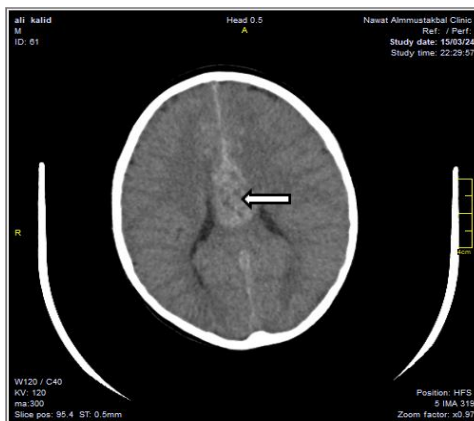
Initial brain CT showed no epidural or subdural hemorrhage, but a traumatic subarachnoid hemorrhage in the interhemispheric fissure with corpus callosum edema.
